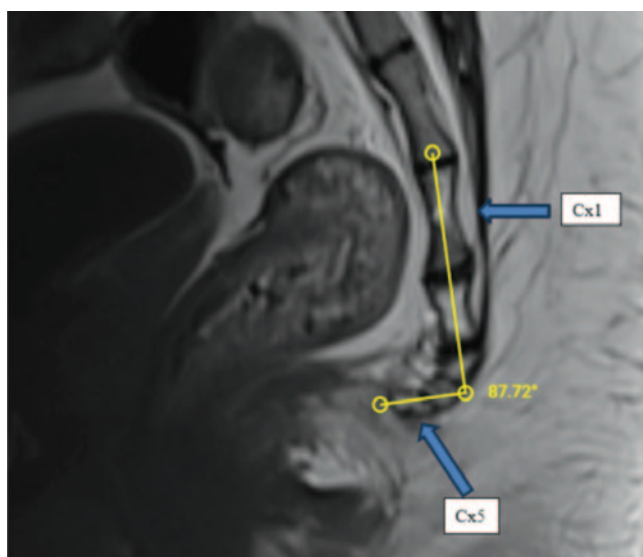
T1-weighted sagittal MRI section. The intercoccygeal angle was measured as the angle formed between the lines drawn through the midpoints of the first and last coccygeal vertebrae. The first coccygeal (Cx1) and fifth coccygeal vertebra (Cx5) are indicated by blue arrows.
